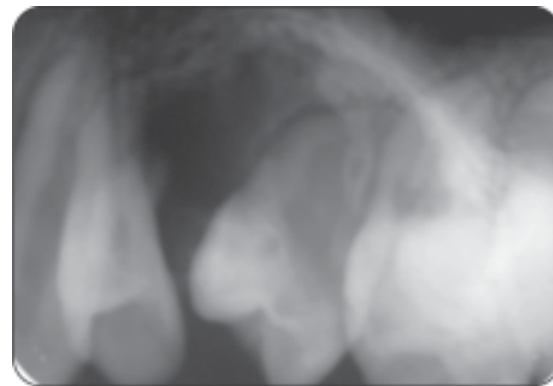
Radiograph of peripheral ossifying fibroma
